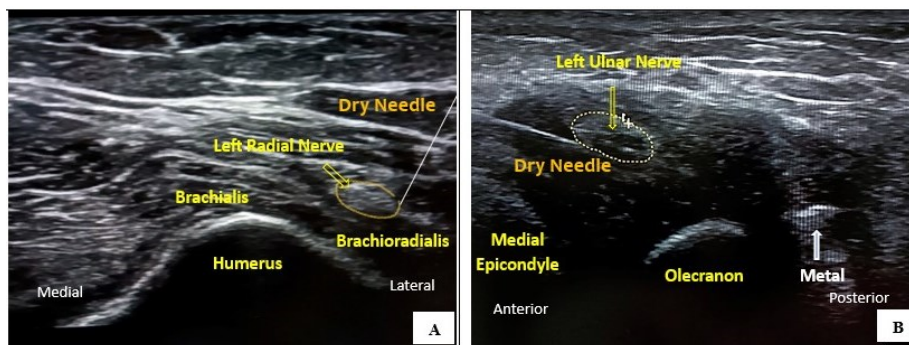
Ultrasound guided nerve dry needling at swollen nerve to release the fascia around the nerve. A. Ultrasound guided dry needling at radial nerve. B. Ultrasound guided dry needling at ulnar nerve.
